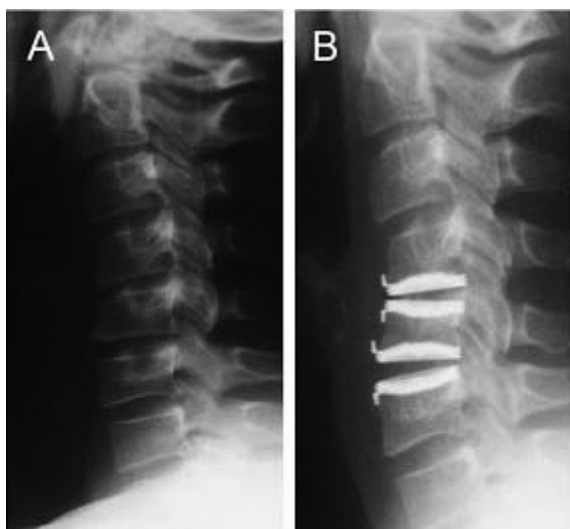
Post-operative change in alignment and motion in multilevel CA: a) pre-operative lateral radiography, b) post insertion of caudal implant, resulting loss of alignment and motion of rostral disc replacement.
